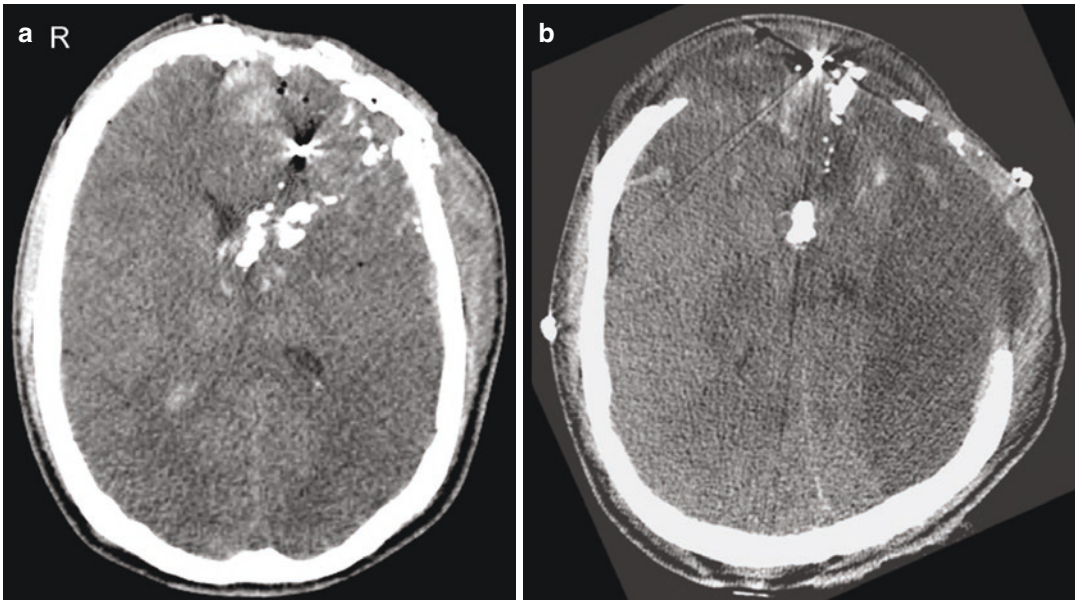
Blast-induced TBI. (a) Non-contrast axial CT images show multiple metallic fragments, comminuted left frontal fractures, left frontal pneumocephalus, and left frontal scalp soft tissue swelling. High-density collection within the occipital horn of the right lateral ventricle indicates acute IVH. (b) Follow-up CT, performed after decompressive craniectomy, reveals left frontal external
